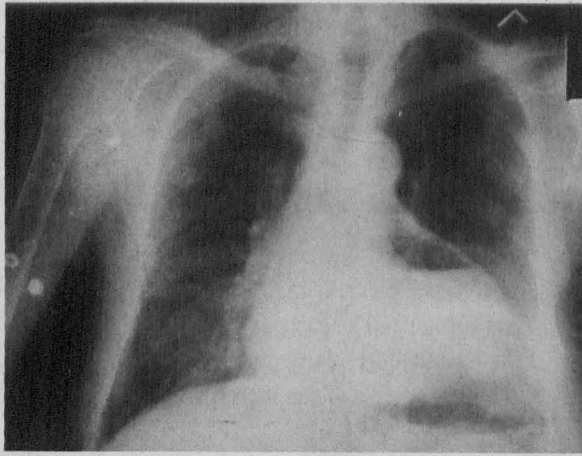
Admission chest radiograph – PA view.
